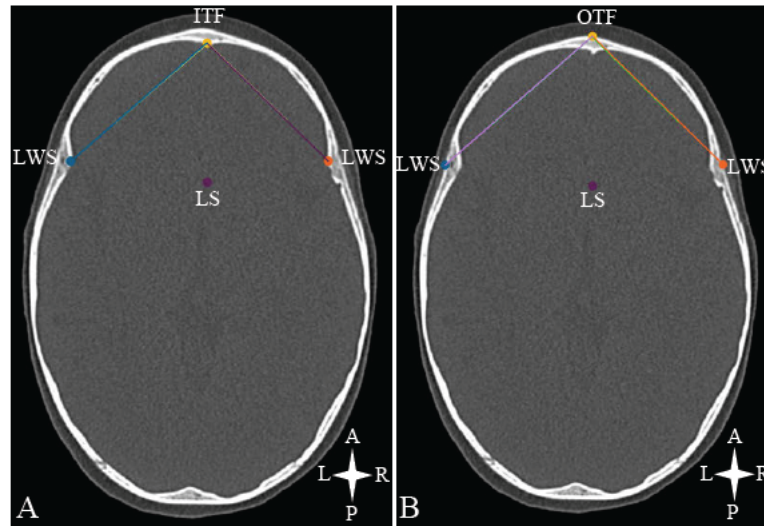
Angles of the ACF on an axial CT scan of a normal patient (EBA: vertex at ITF and terminal points at LWS; FA: vertex at OTF and terminal points at LWS). Key: ITF – inner table of frontal bone; OTF – outer table of frontal bone; LWS – lesser wing of sphenoid bone; LS – midpoint of limbus sphenoidale (transcended landmark used as a reference plane)
